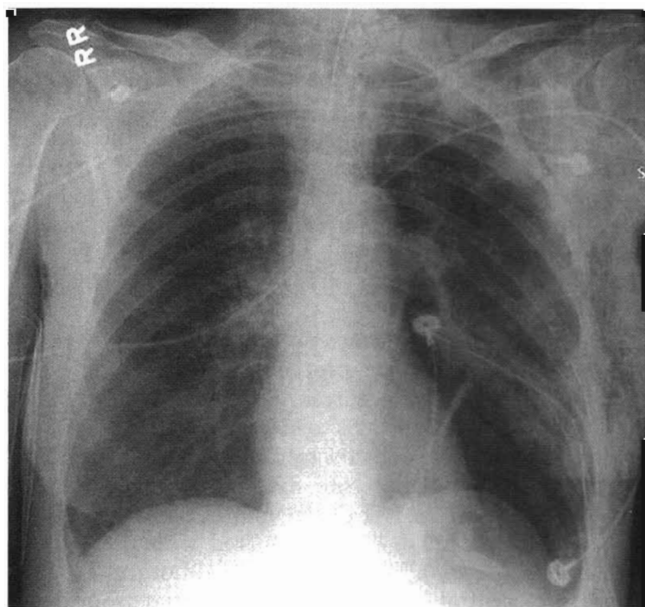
A supine chest radiograph shows evidence of a deep sulcus sign on the left consistent with the presence of a pneumothorax.
